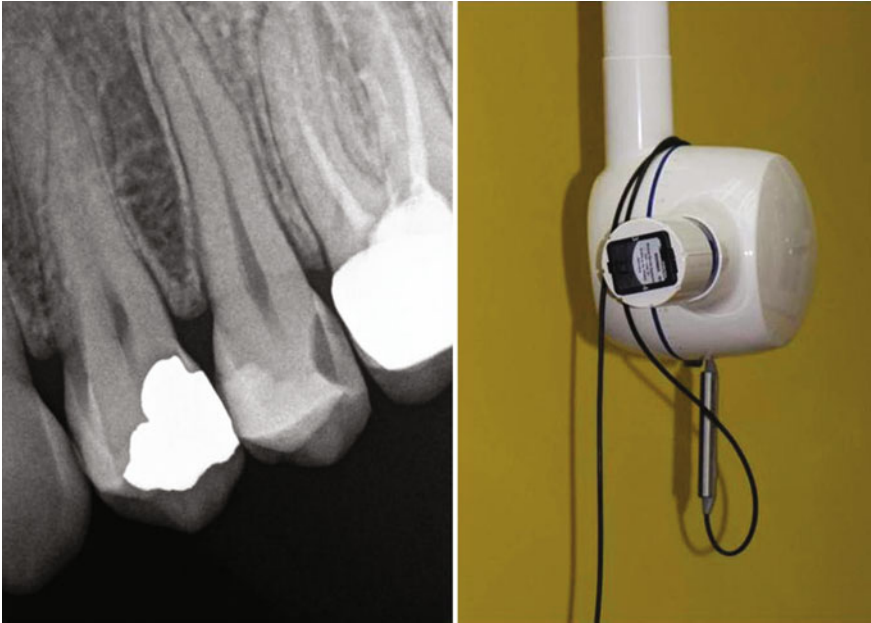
Intraoral radiography
